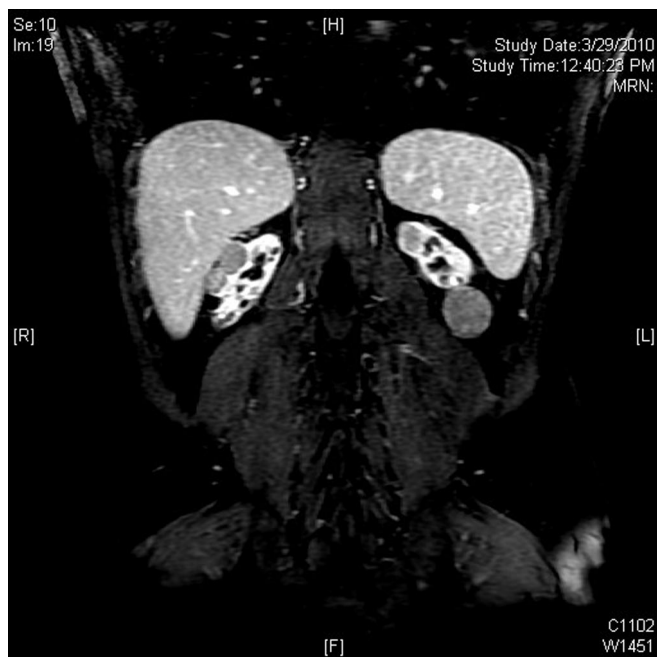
Coronal image from MRI of the abdomen/pelvis demonstrating atrophic native kidneys with enhancing solid tumors in both kidneys (here, 2 on the right mid-upper pole and 1 on the left upper pole), the largest measuring 3cm x 2.8cm x 3.2cm.
